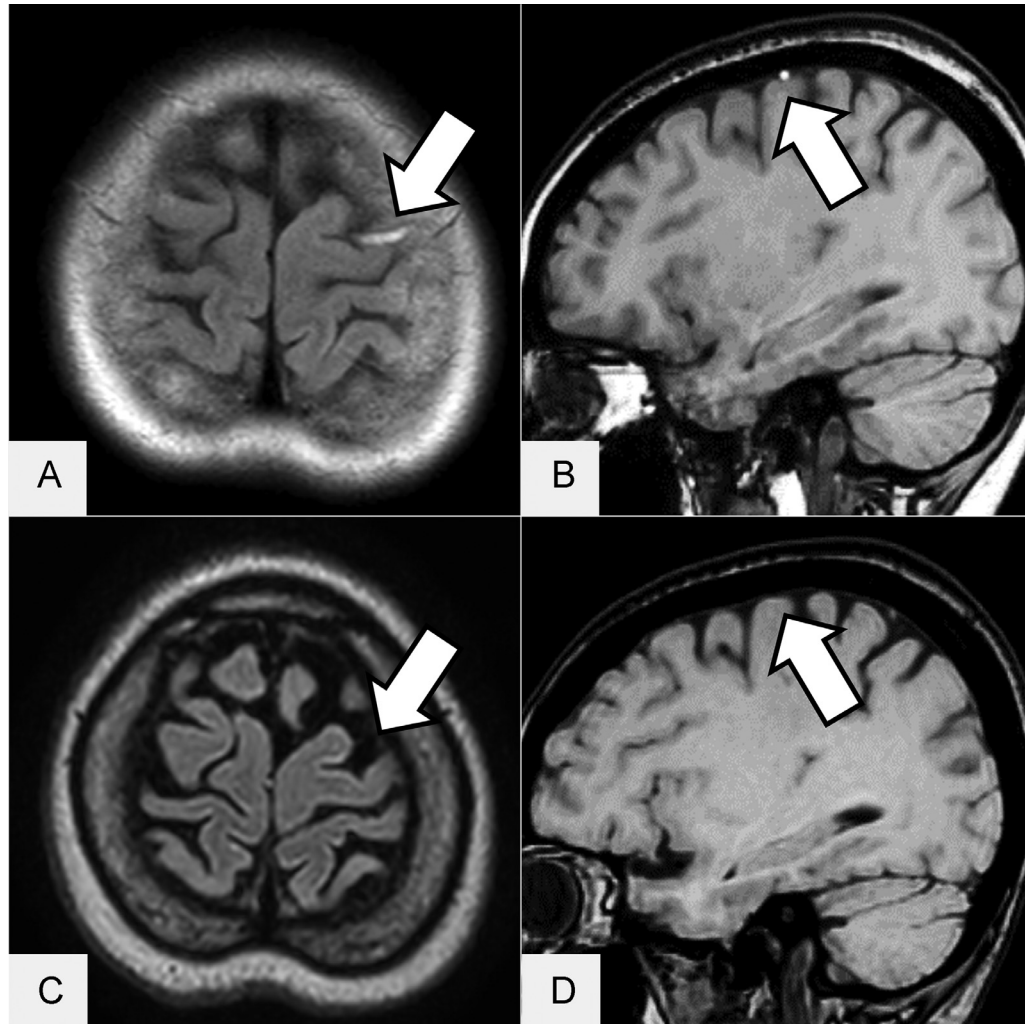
Signal changes in cord sign (arrows) on fluid-attenuated inversion recovery (FLAIR) and magnetic resonance venography (MRV) on Days 17 and 112 after onset. On the 17th day, an increased intensity in the signal detected on fluid-attenuated inversion recovery imaging (A), accompanied by the appearance of a heightened signal on MRV (B), was observed. On the 112th day, the heightened signal observed on FLAIR imaging at the location of the thrombus had vanished (C), and the signal on MRV had transitioned to an isointense state, rendering it challenging to differentiate from typical vessels (D).
